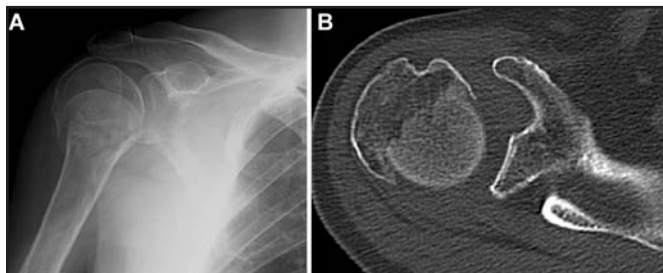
Four part valgus fracture = three fragment fracture C/D/Tt. The possible four-part valgus fracture is converted to a three-fragment fracture with only one fragment displaced, the humeral head. (A) The tuberodiaphyseal relationship is greater tuberosity without displacement. The cephalotuberosity relationship is displacement of the head in relation to the tuberosities but not the tuberosities. The cephalodiaphyseal relationship is impacted and displaced fracture in valgus of the humeral head over diaphysis with internal fulcrum conserved. X-ray, AP view. (B) There is no fracture between tuberosities here. The classification is C/D/Tt. There are three fragments, articular, without fracture between tuberosities. This type of fracture is not very frequent but it is possible, and is included in the fourteen possible upper humeral fractures. The cephalotuberosity relationship is humeral head displacement. CT scan, axial view.
